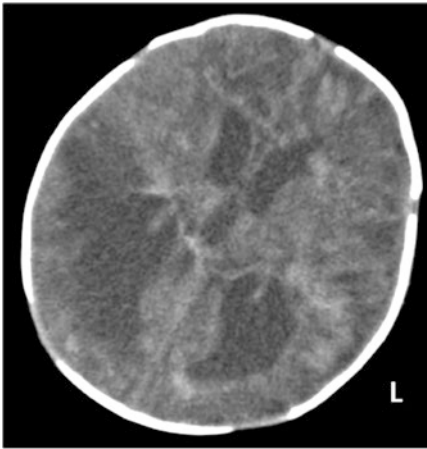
The brain CT scan on admission
